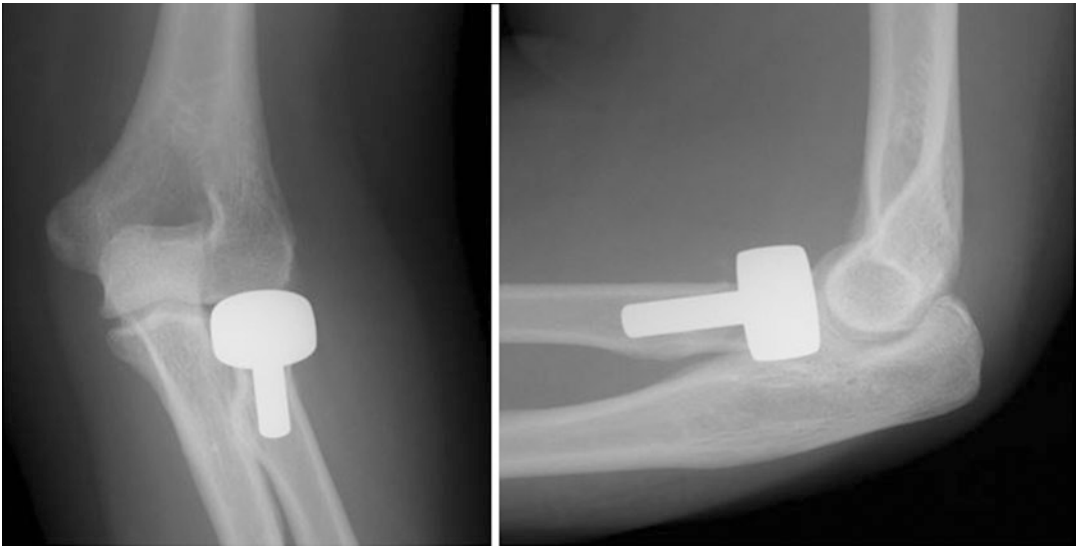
Post-operative AP (left) and lateral (right) radiographs of the elbow. These images demonstrate a parallel medial ulnohumeral joint and an implant well aligned with the capitellum
